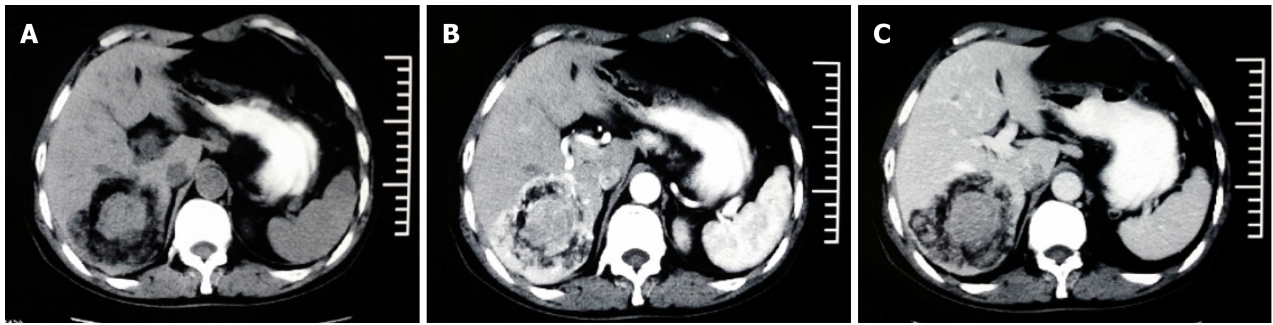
Computed tomography scans of the right hepatic lobe of a 72-year-old male patient with PEComa (patient 10). A: Plain computed tomography scan showing an irregular soft tissue density shadow; B: Enhanced scan showing obvious enhancement of the mass margin and of central heterogeneity in the arterial phase; C: Portal vein scan showing a low mass density.
